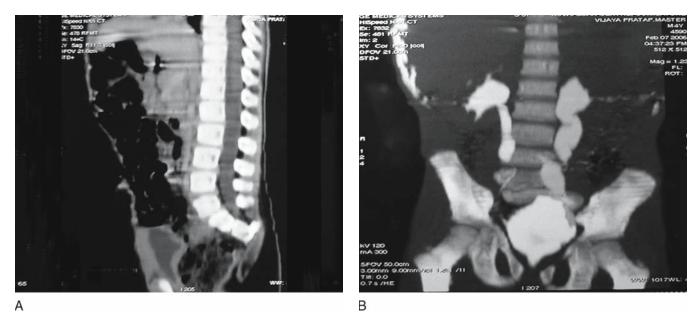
A computed tomography (CT) urogram reveals sacral agenesis with bilateral dilated ureters
